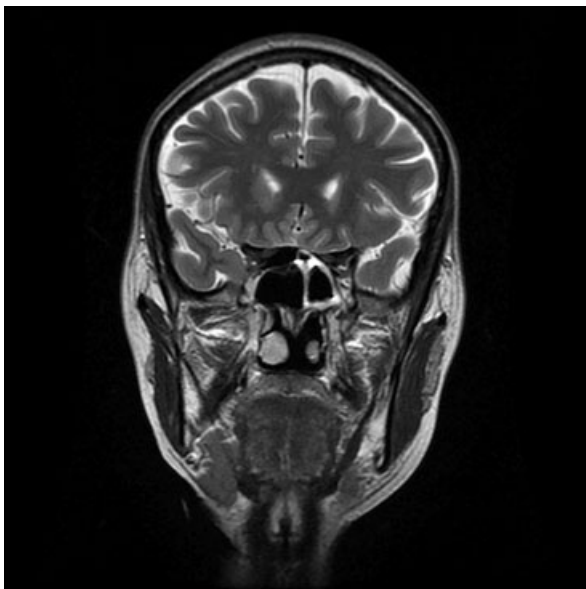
MRI scan of the head showing invasive aspergillosis and fungal osteitis of the lateral wall and the roof of the left sphenoidal sinus, and inflammatory alterations of the left cavernous sinus, internal carotid artery, and left abducens nerve.
